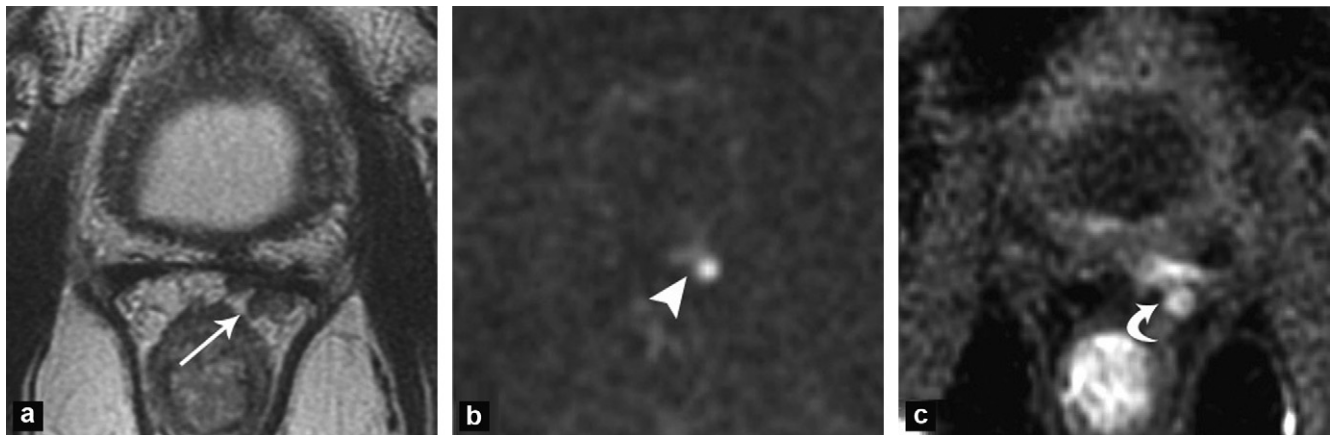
A 70-year-old patient who had had a radical prostatectomy and radiotherapy 3 years previously for a Gleason 7 pT3a prostatic adenocarcinoma. The PSA nadir was 0 ng/mL. Gradual increase to 1.48 ng/mL, with the appearance of a left nodule on DRE: a: T2-weighted axial magnetic resonance imaging (MRI) showing a nodule with an intermediate signal in the left vesicorectal angle (arrow); b: diffusion-weighted axial slice ($b = 2000\text{s/mm}^2$): the nodule exhibits clear diffusion restriction (arrowhead); c: dynamic axial slice after contrast agent injection: enhancement is early and intense (curved arrow). Biopsy of the nodule showed a Gleason 8 adenocarcinoma.
